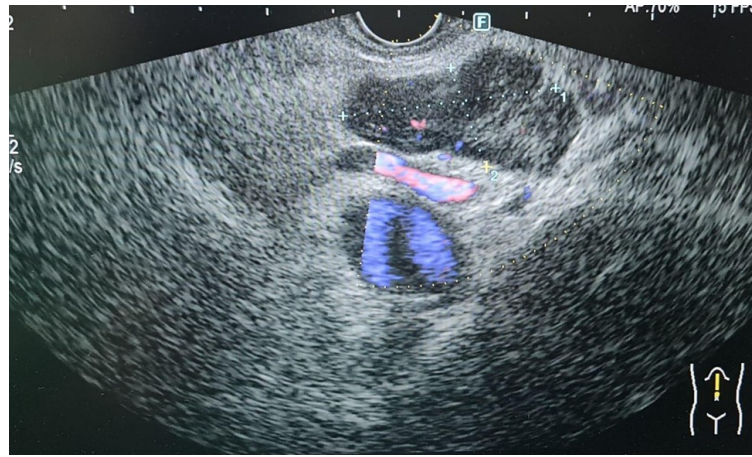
Endoscopic ultrasound showing enlarge lymph nodes.
